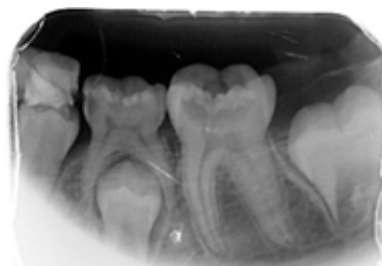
Periapical radiograph of tooth 3.6 with 37 months of evolution.*
